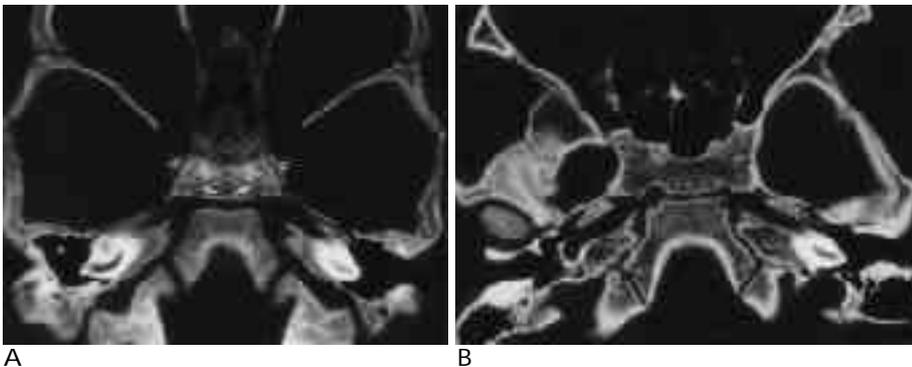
The lateromedial postsphenoidal synchondrosis and basisphenoidal-alisphenoidal synchondrosis. A. Axial CT scan in a 2-month-old male infant shows fusion of the lateromedial postsphenoidal synchondrosis (arrows) earlier than that of the basisphenoidal-alisphenoidal synchondrosis (small double arrows). B. Axial CT scan in a 3-year-old girl shows complete fusion of both synchondroses.
